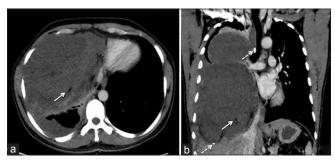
(a and b) Contrast-enhanced computed tomography chest, axial and coronal sections, showing a large, right pleural-based, heterogeneous, hypodense mass lesion with few fat-containing areas (solid arrows) and few calcific foci (dashed arrows). This lesion is involving the almost entire right hemithorax with the underlying collapse of the right lung and mild right pleural effusion
